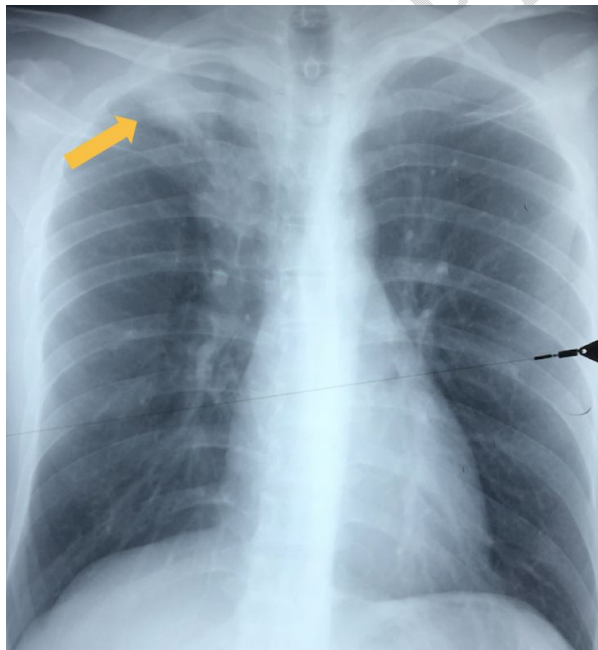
Chest X-ray showing a parenchymal lesion of the right upper pulmonary lobe.
